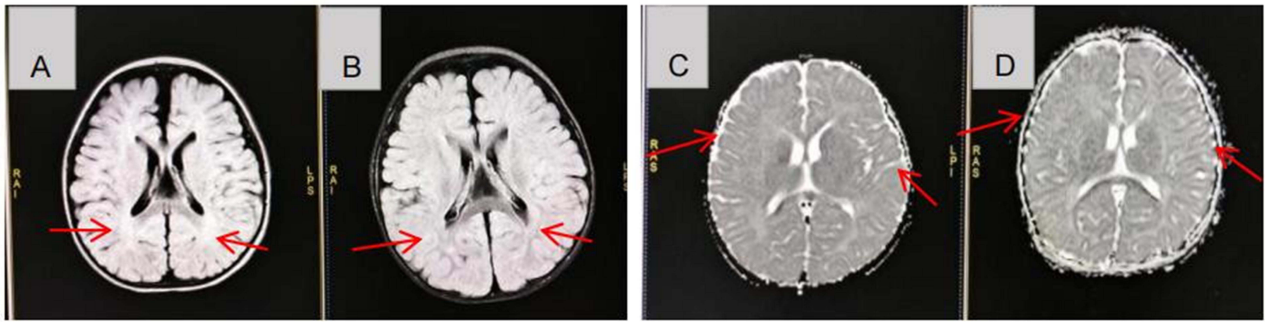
Comparison of MRI changes before and after treatment in two cases. (A) T2 fluid attenuated inversion recovery images of subject no.20 before treatment, showing high signal intensity near the lateral ventricle and dysplasia indicative of myelin deficiency; (B) Improvements after 90 days of treatment (red arrow). (C) A slightly wider frontotemporal space in the apparent diffusion coefficient map of subject no.36 before treatment; (D) MRI changes after 90-day of treatment, showing improved white matter in the right temporal lobe (red arrow).
